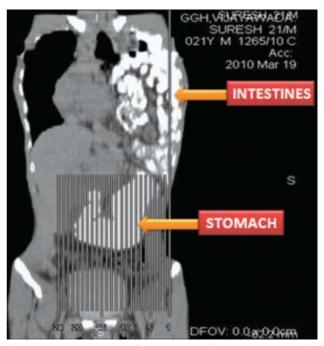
Reconstructed image of CT oral contrast showing interstines in the left hemi-thorax and stomach in the lower abdomen.
